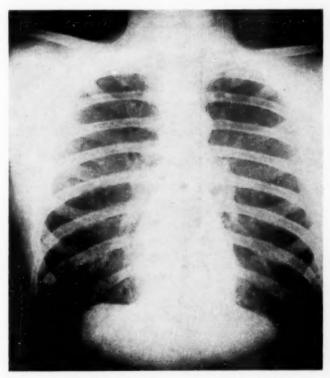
Chest roentgenogram three days after attack. A reticular density is present in the outer portion of the mid-right lung, suggesting multiple small emboli.
